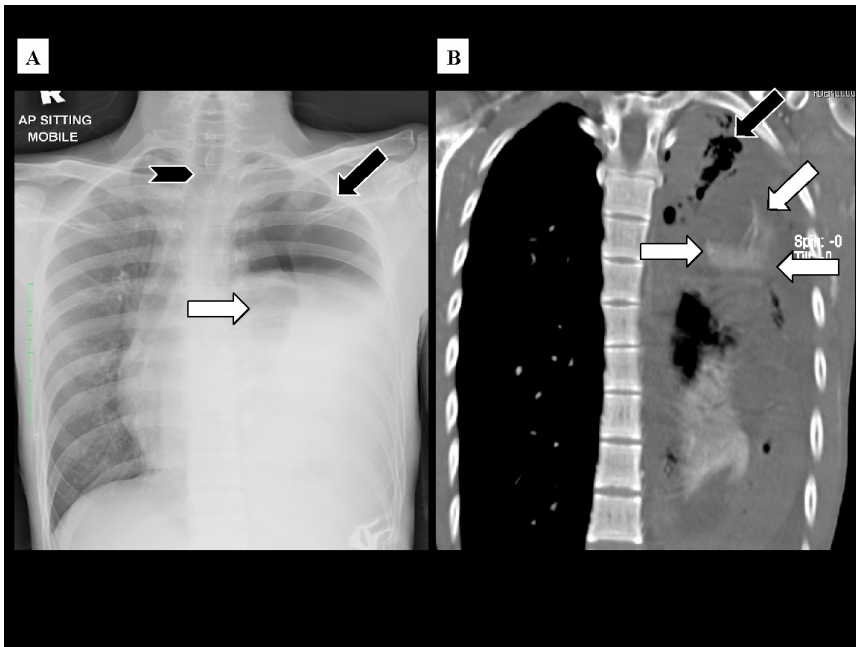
CXR in casualty showed left hydropneumothorax; pneumothorax (black arrow) with fluid level within (white arrow) and tracheal deviation to the right (notched arrow) (A). Coronal CT Thorax image in delayed images showing pooling of contrast in the left upper hemithorax (white arrow) and air pockets within the effusion confirming the pneumothorax component (black arrow) (B)
